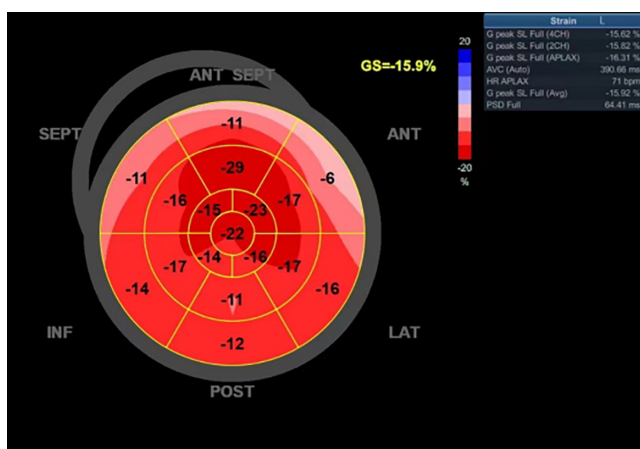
The speckle tracking echocardiography showed a reduction in longitudinal strain with apical sparing.
